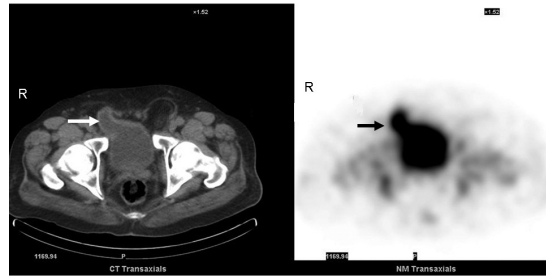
Fused SPECT-CT (axial images) confirms that the focal Tc MDP localization in pubic region corresponds to radioactive urine in the herniated urinary bladder in right inguinal canal. Herniation of bowel loops into the left inguinal canal can also be made out in the CT images.
